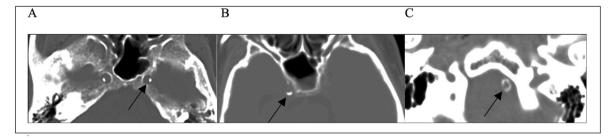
Examples of IAC scores on CT image.
